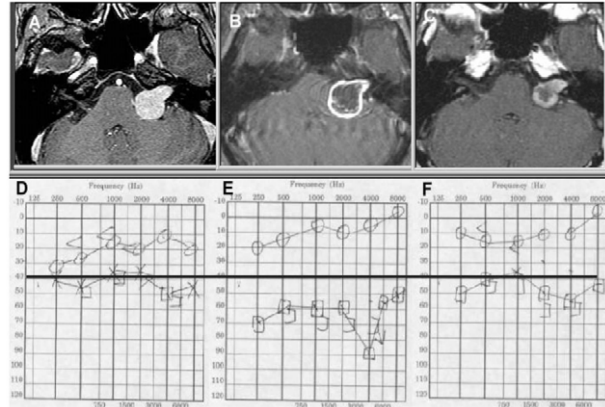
Axial plane, contrast-enhanced magnetic resonance images obtained in a 25-year-old man who underwent gamma knife radiosurgery (12 Gy at margin; 50% isocenter): (A) left-sided acoustic neuroma; (B) swollen tumor was seen 6 months after treatment; (C) tumor regression was noted 12 months later. (D, F) Preoperative hearing level was maintained after treatment, although (E) transient impairment was noted at the sixth month.
